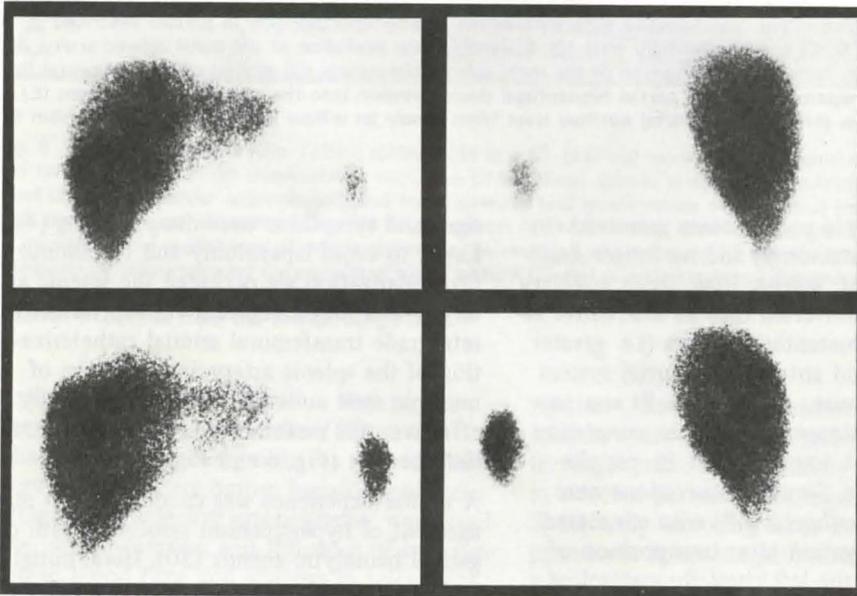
Anterior (left) and posterior (right) splenic scintigraphy (^{99m}Tc sulfacolloid), 10 days (above) and 2 months (below) after ligation of the upper pole branch of the splenic artery for control of splenic hemorrhage from traumatic rupture. Note gradual intensification of splenic reticuloendothelial radionuclide trapping (? improved blood flow or regeneration) with preservation of a sizable splenic fragment
